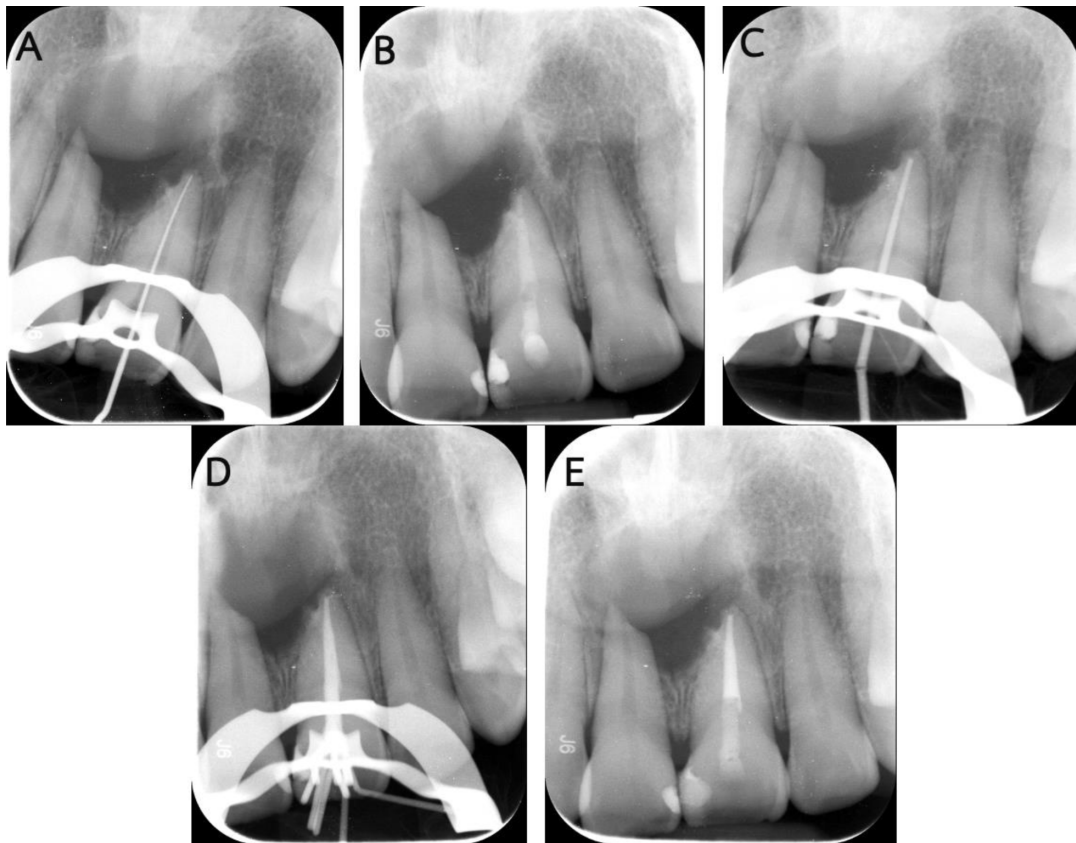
Radiographic images of clinical procedures: (A) Working length determination, (B) Absence of calcium hydroxide washout from the root canal, (C) Try main cone, (D) Root canal filling, (E) Final radiograph.
